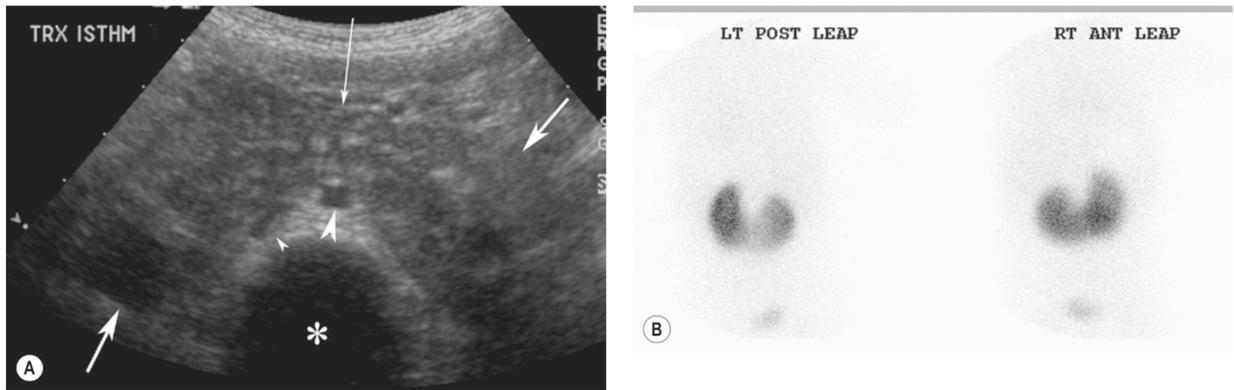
Sonographic image represent horseshoe kidney (two solid arrows on the right and left) with isthmus (long arrow) that made of normal renal parenchyma. Isthmus of the horseshoe kidney is in the proximity of the inferior vena cavae (small arrow head) and abdominal aorta (large arrow head). Static renal scintigraphy demonstrate isthmus in made of functioning renal parenchyma tissue.
